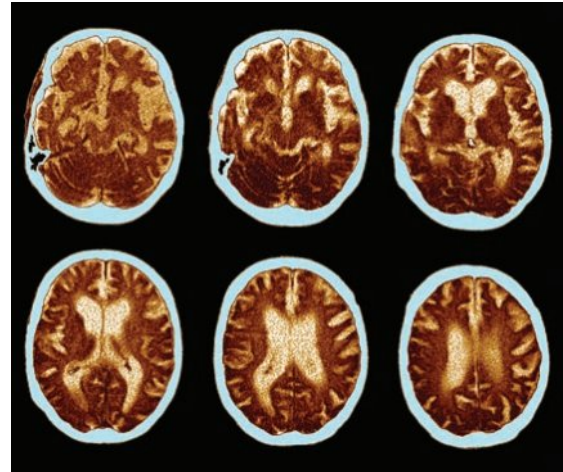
13 An example of images produced by a CT scan
